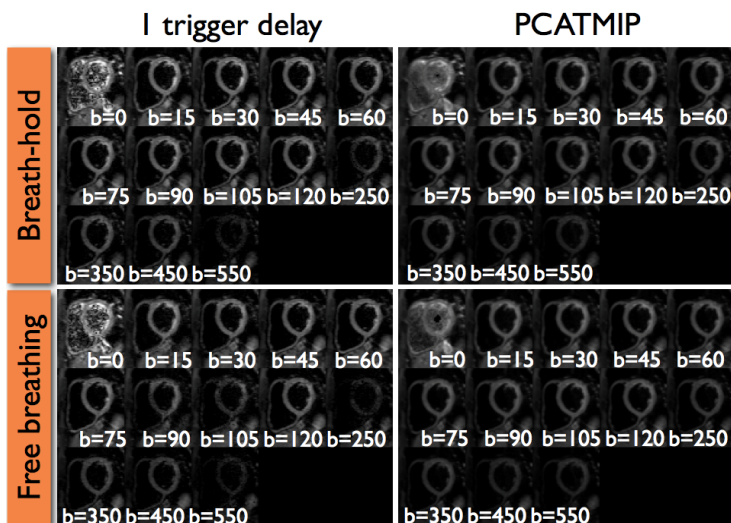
Examples of DWI scans for 1 diastolic trigger delay and after PCATMIP for acquisitions performed during BH and FB. Indicated b-values are in s/mm².
